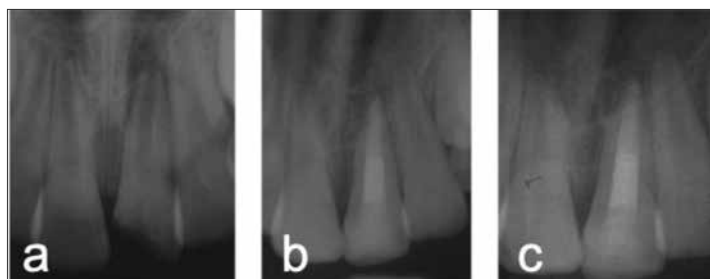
Radiographic appearance of case 6; a – preoperative; b – postoperative; c – postoperative 24-month follow-up
